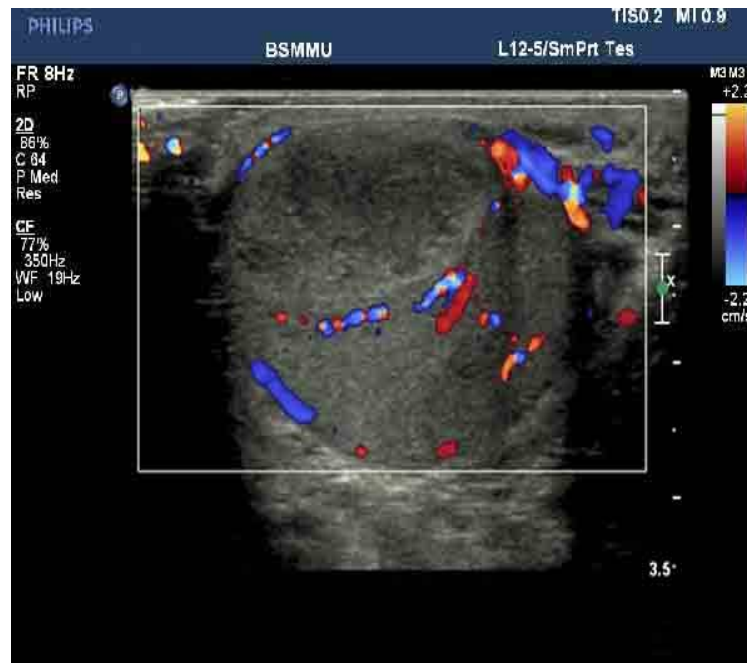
Testicular abscess-Color Doppler scan showing mixed echogenicic testis with increased peripheral vascularity.
